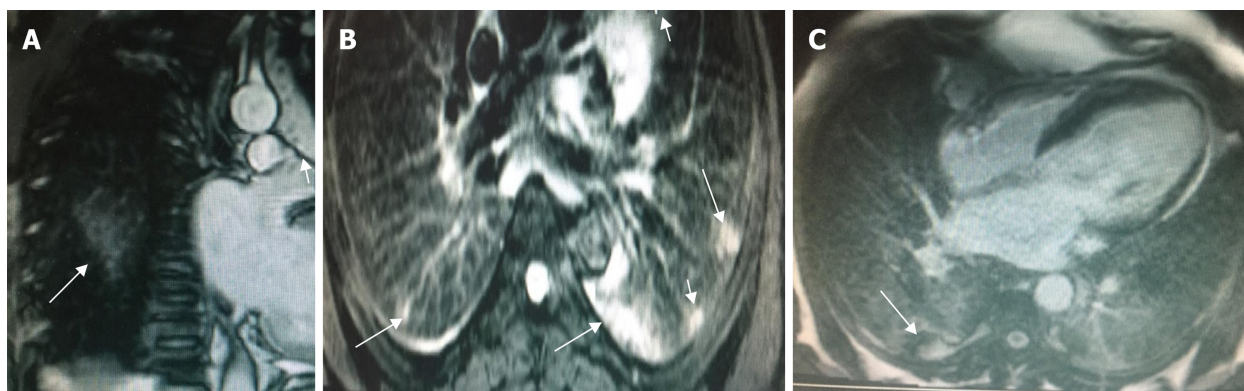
Cardiac magnetic resonance images of a patient with coronavirus disease 2019 who presented to our institute for a viability study showing multifocal peripheral areas of abnormal signal in both lungs that appear as high signal intensity areas localized in the coronal plane (A), high T2 signals (B), and faint heterogenous enhancement in post-contrast sequences (C).
